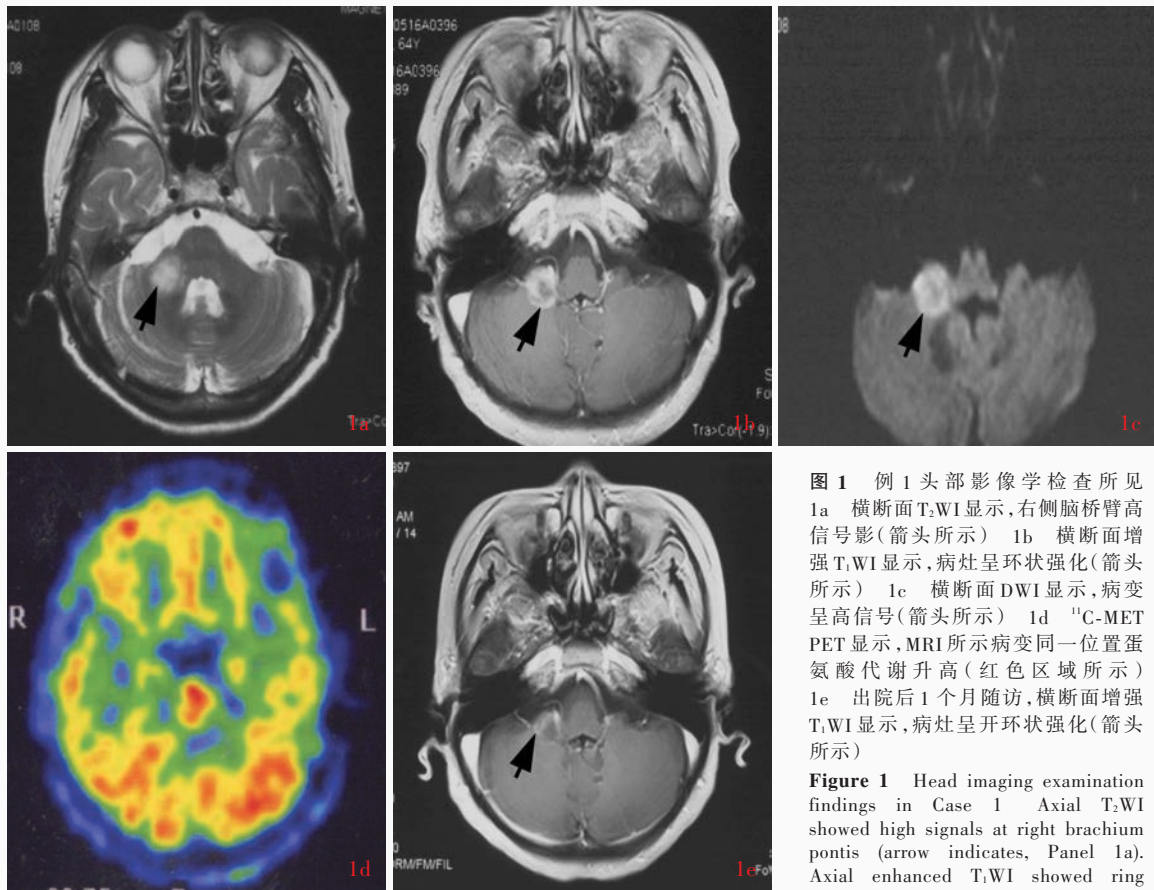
例 1 头部影像学检查所见 1a 横断面 T₁WI 显示, 右侧脑桥臂高信号影(箭头所示) 1b 横断面增强 T₁WI 显示, 病灶呈环状强化(箭头所示) 1c 横断面 DWI 显示, 病变呈高信号(箭头所示) 1d ¹¹C-MET PET 显示, MRI 所示病变同一位置蛋氨酸代谢升高(红色区域所示) 1e 出院后 1 个月随访, 横断面增强 T₁WI 显示, 病灶呈开环状强化(箭头所示)
